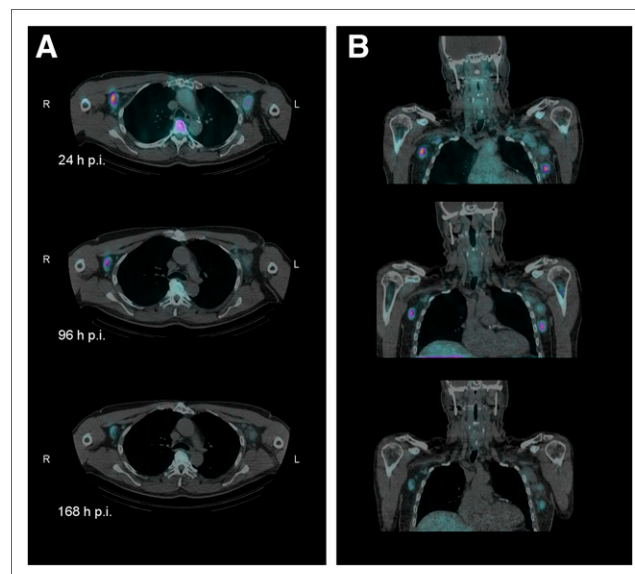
Axial (A) and coronal (B) SPECT/CT-fused images of patient 13 at 3 time points after administration of ¹⁷⁷Lu-lilotomab satetraxetan. Tumor 13b can be seen in left axilla and 13c in the right. Tumor dosimetry was based on multiple SPECT/CT scans. p.i. = after injection.
